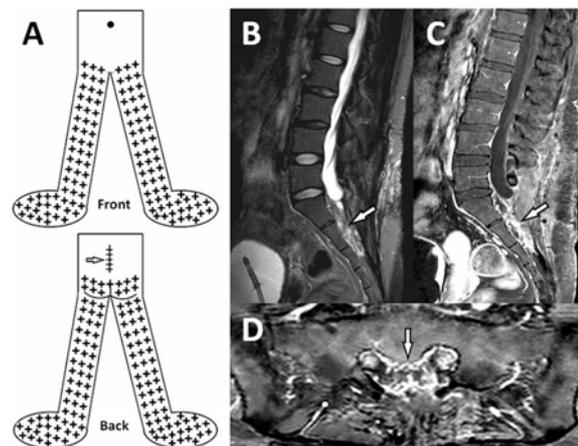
Clinical and radiographic findings: (A) Area of neuropathic pain in front (anterior) and back (posterior) views, surgical scar (arrow); (B) lumbosacral spinal MRI in sagittal T2WI, (C) sagittal T1WI with contrast and (D) axial T1WI with contrast showing marked fibrosis (arrow) within the S1-S3 spinal canal.
